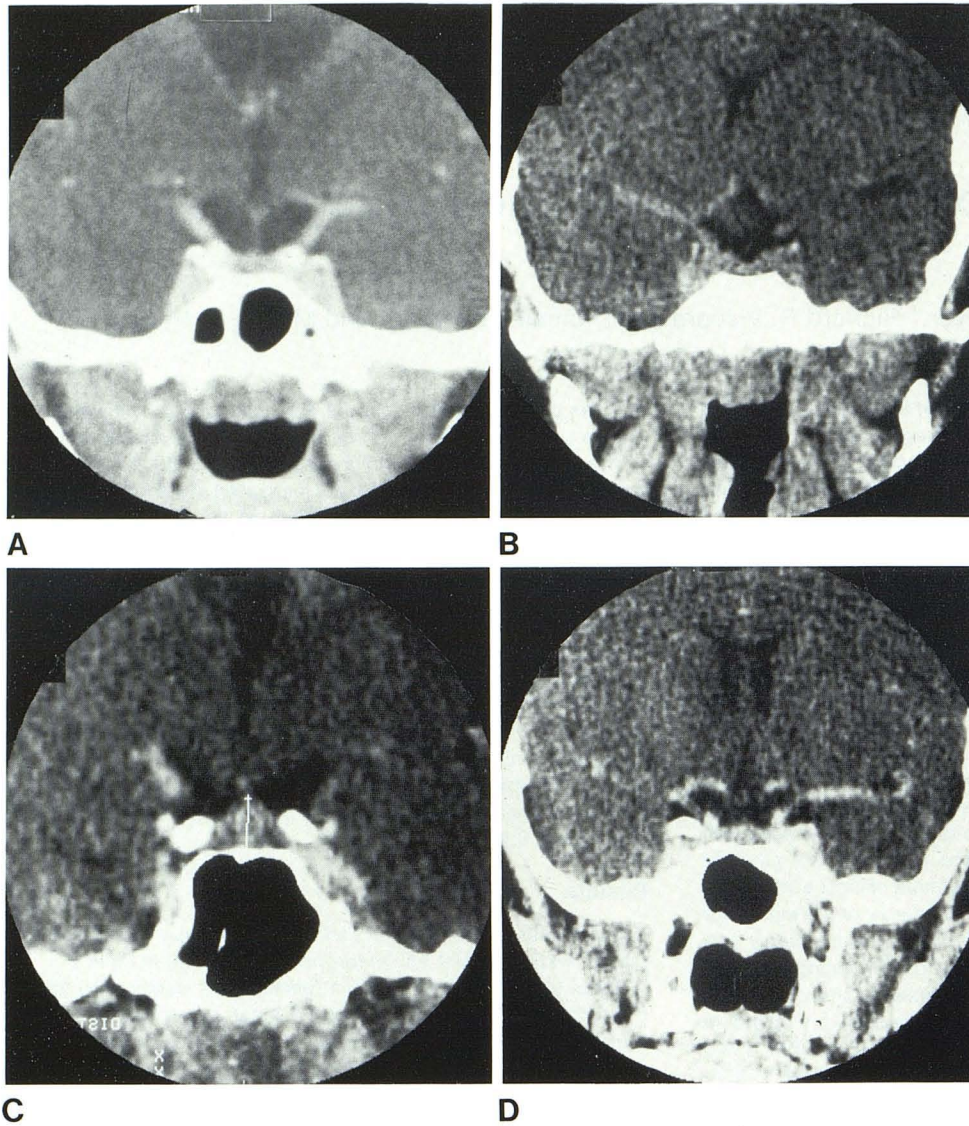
CT scans of pituitary gland. A, "Normal" gland with flat superior margin. Gland height, 4 mm. 5 mm coronal section, magnification $\times 2.3$. B, "Normal" gland with concave superior margin. Gland height 3.5 mm. 1.5 mm coronal section, magnification $\times 2$. C, "Abnormal" gland in 21-year-old man. Convex superior margin. Gland height, 8 mm. 1.5 mm coronal section, magnification $\times 3$. (Note cursor used for gland height measurement.) D, "Questionable" gland in 14-year-old boy. Slightly convex superior margin. Gland height, 6 mm. 1.5 mm coronal section, magnification $\times 2$.
